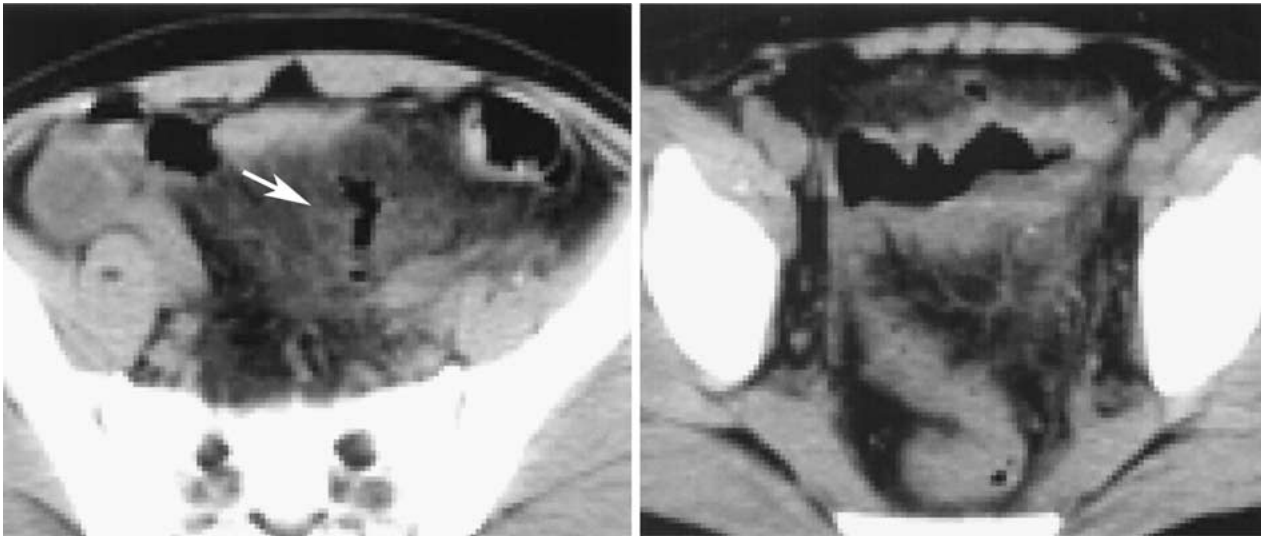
CT images of perforated sigmoid colonic diverticulitis (Left cephalad to Right). Prominent mural thickening of the sigmoid colon and hazy density of the surrounding fat tissue are observed. Extraluminal air adjacent to the sigmoid colon (pneumoretroperitoneum) is seen (*arrow*).
